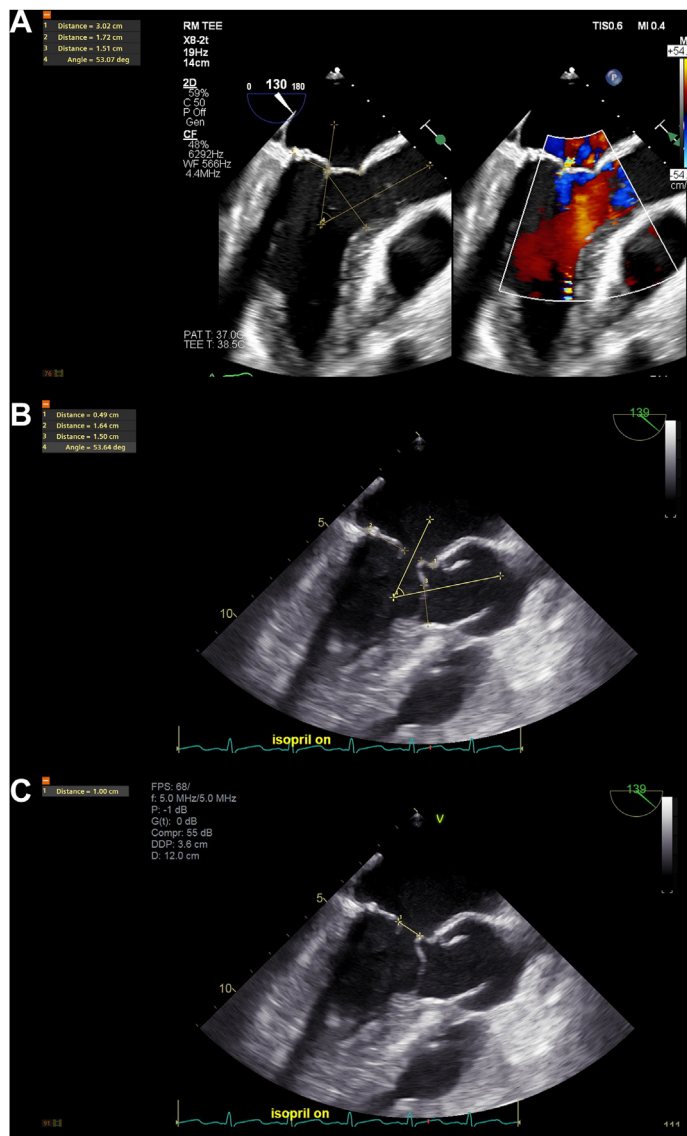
Intraoperative Transesophageal Echocardiogram Stills Showcasing Quantitative Measurements of MV Anatomy
